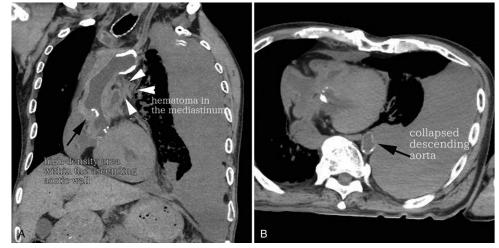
A 72-year-old male with type A AAD. A. PMCT images show a high-density area within the ascending aortic wall (arrow), indicating type A AAD with a closed false lumen. A large amount of left-sided bloody pleural effusion is seen. There is also a hematoma in the mediastinum (arrowheads) and a small amount of bloody pericardial effusion. These findings may suggest that intrapericardial blood has passed through the pericardium and flowed into the left thoracic cavity due to CPR. B. CT image shows bloody left-sided pleural effusion. The descending aorta has collapsed (arrow).
